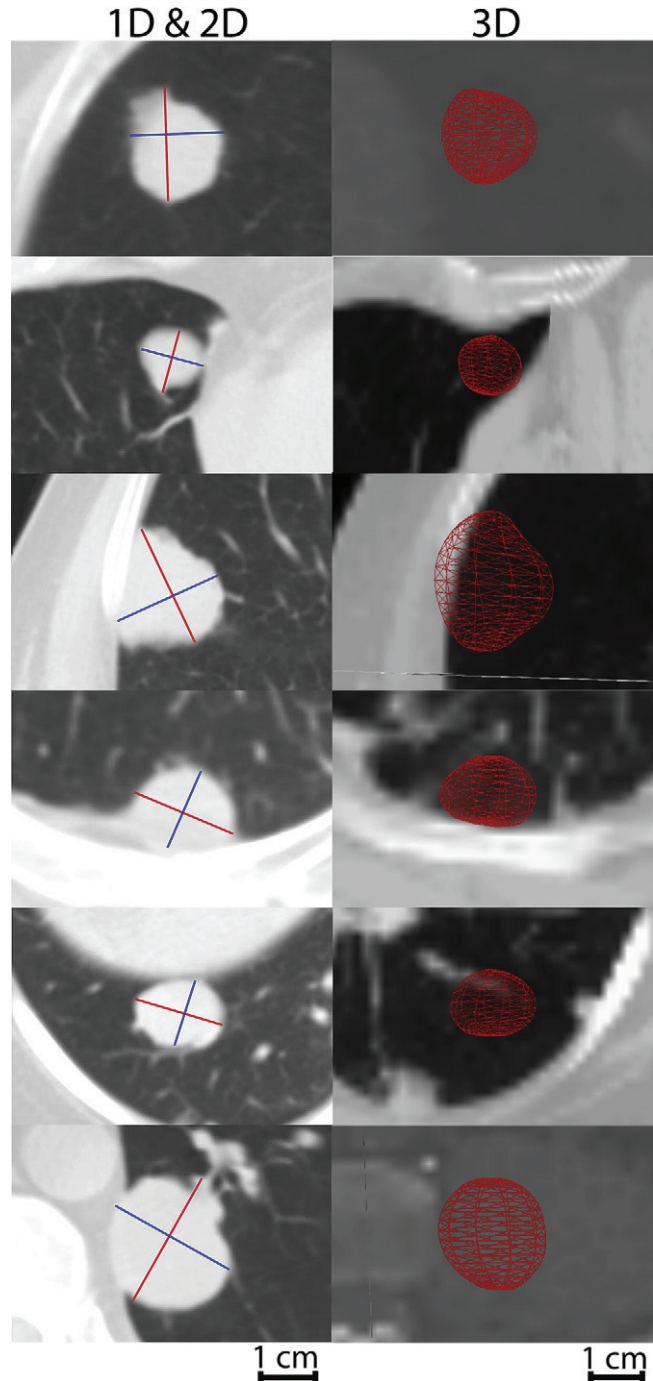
Computed tomography images of six representative patient lung tumors with one-dimensional, two-dimensional (*left panel*), and three-dimensional measurements (*right panel*).
